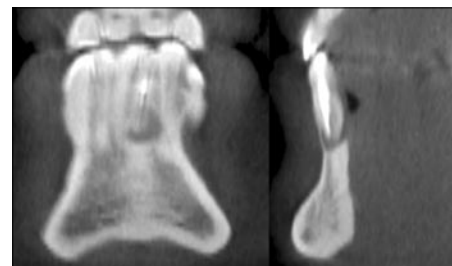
CBCT views of mandibular incisor periapical lesion from the same patient pictured in Figure 3a (courtesy of Dr. Vaziry).
